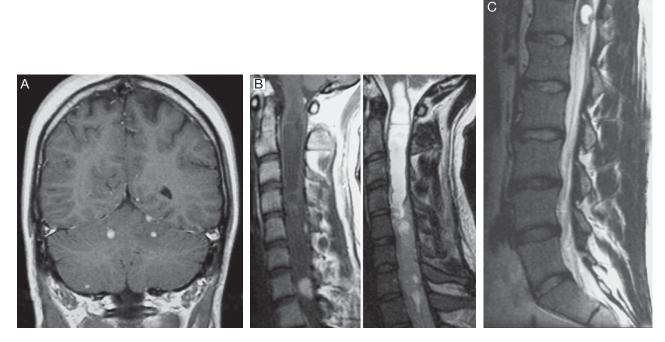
Magnetic Resonance Images of Hemangioblastoma.
